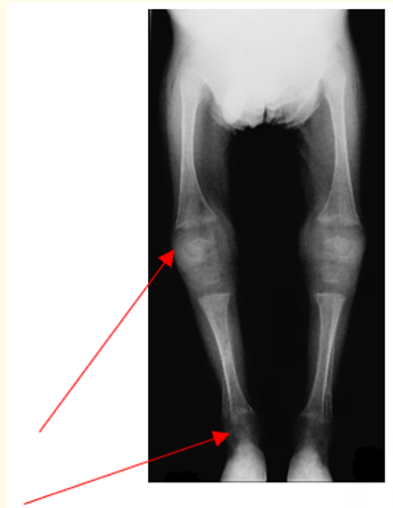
The x-ray showed signs of rickets.
